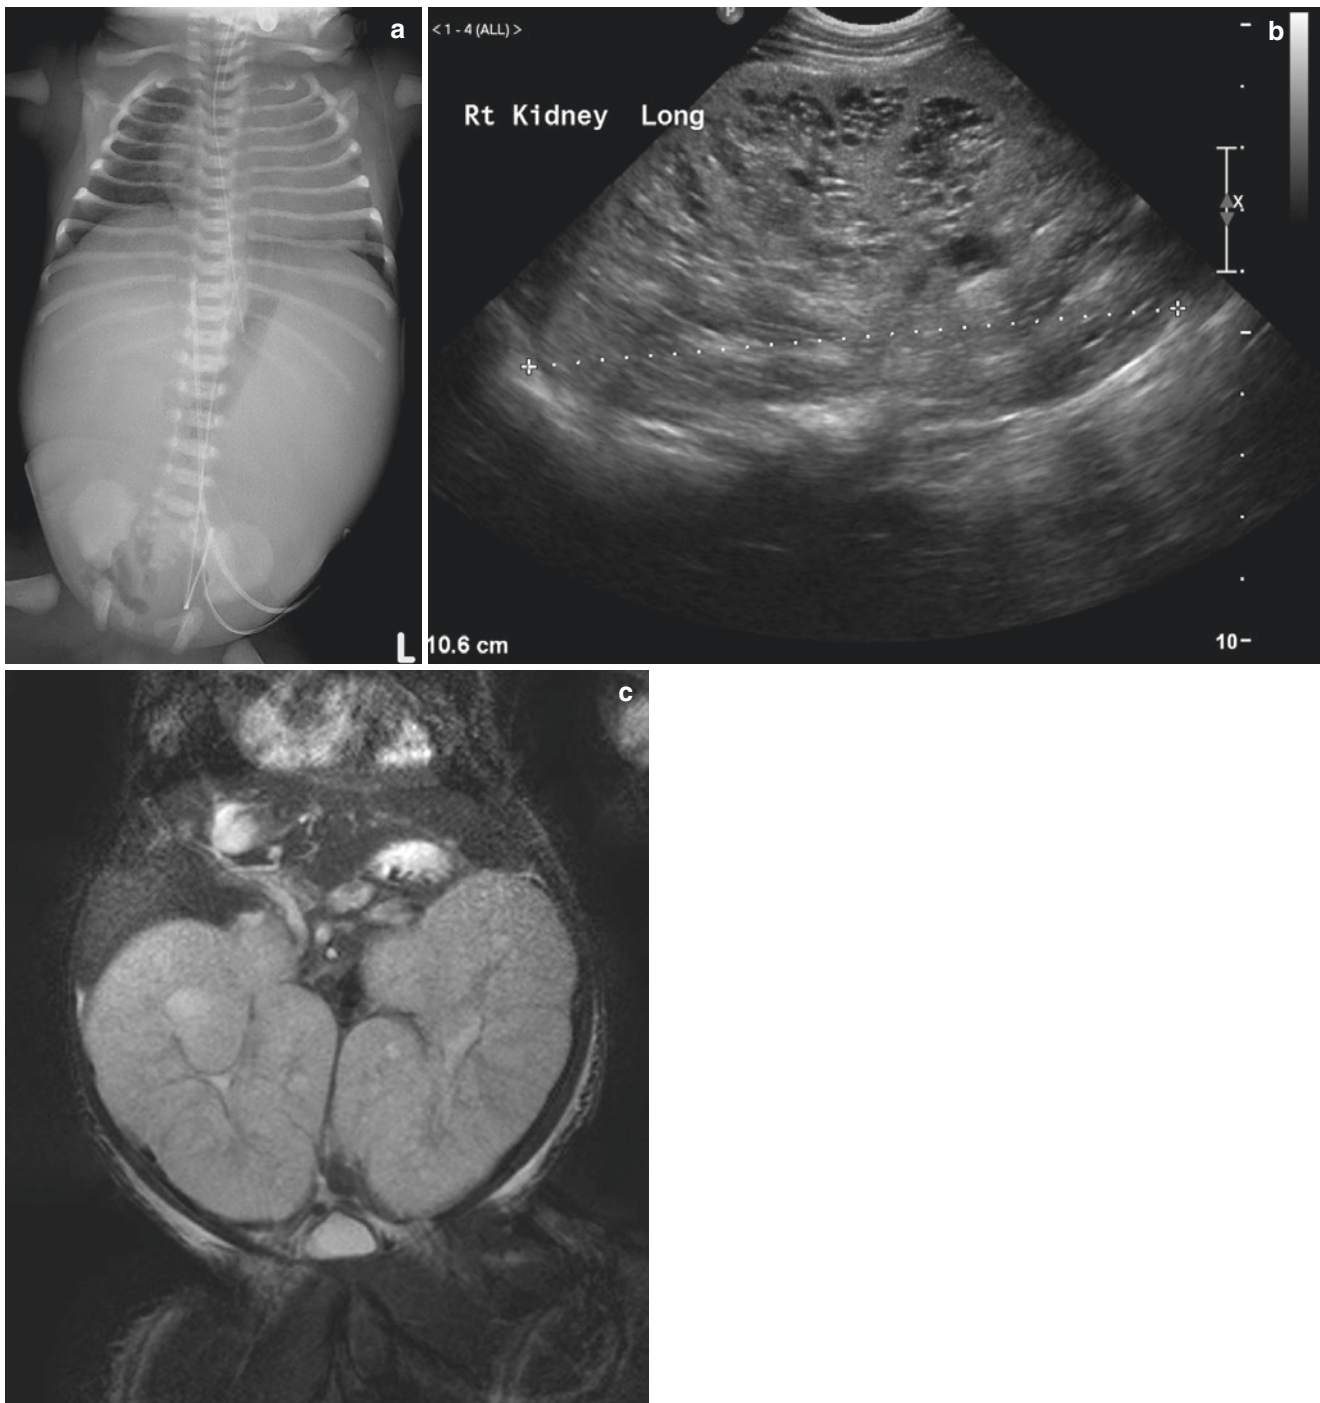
(a) Plain X-ray of autosomal recessive polycystic kidney disease. The abdomen is distended by bilateral soft tissue densities, with medial displacement and distortion of the stomach bubble. The lungs are of low volume. (b) Longitudinal ultrasound image of an autosomal
